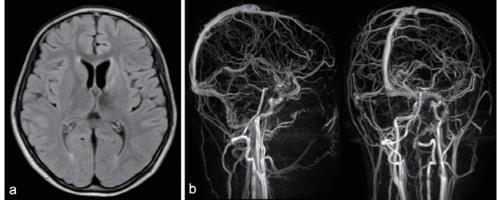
(a) Fluid-attenuated inversion recovery (FLAIR) at 3 months after mechanical thrombectomy reveals the disappearance of high-intensity lesions. (b) Magnetic resonance venography shows complete recanalization of the straight sinus.
